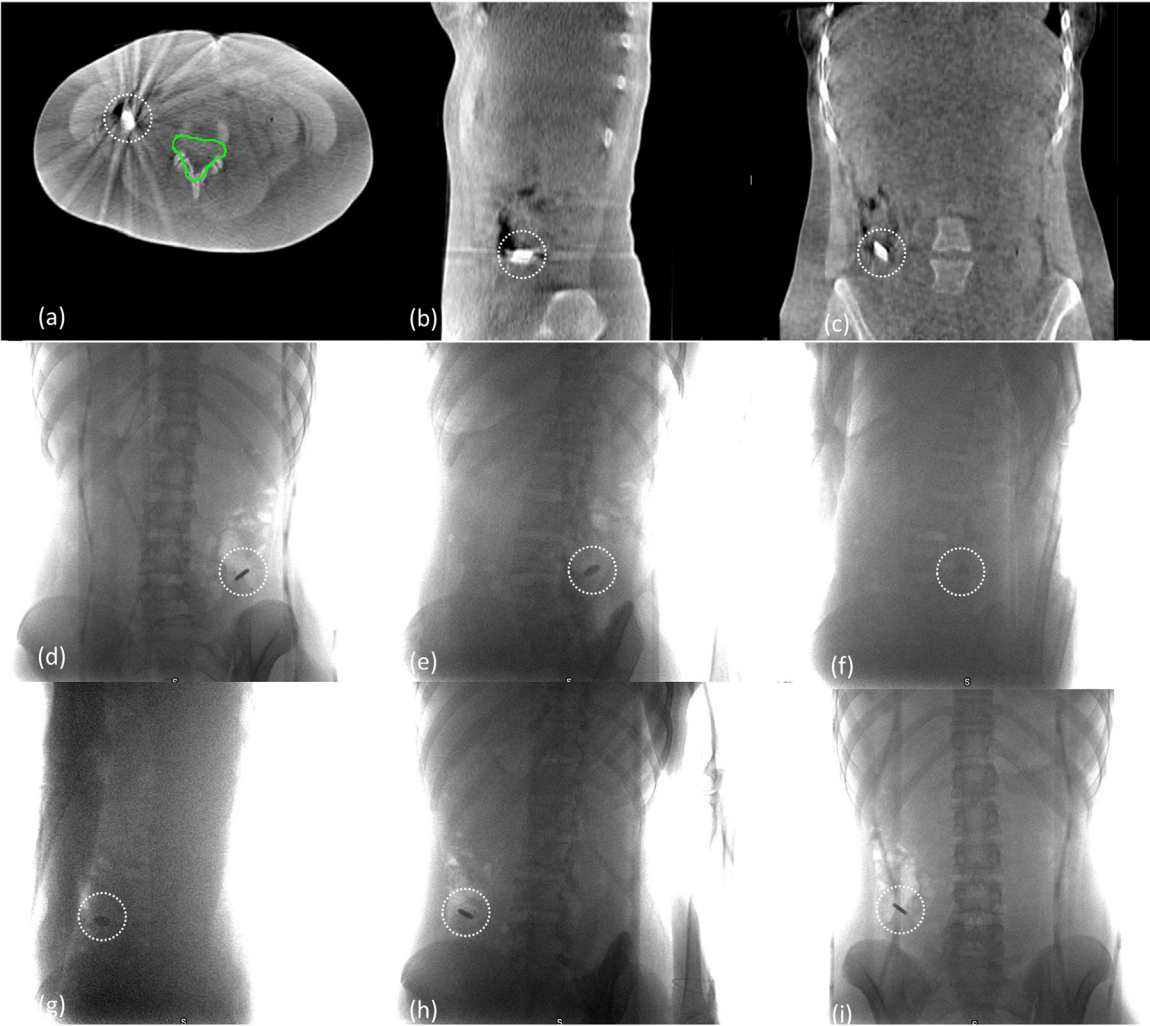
Raw projection and reconstructed images used to evaluate the geometric and radiological characteristics of the artificial object. The cone-beam computed tomography images show the object from (a) axial, (b) sagittal, and (c) coronal views. The radiograph tube was for the raw project images positioned at (d) 355°, (e) 325°, (f) 300°, (g) 260°, (h) 220°, and (i) 185°.
